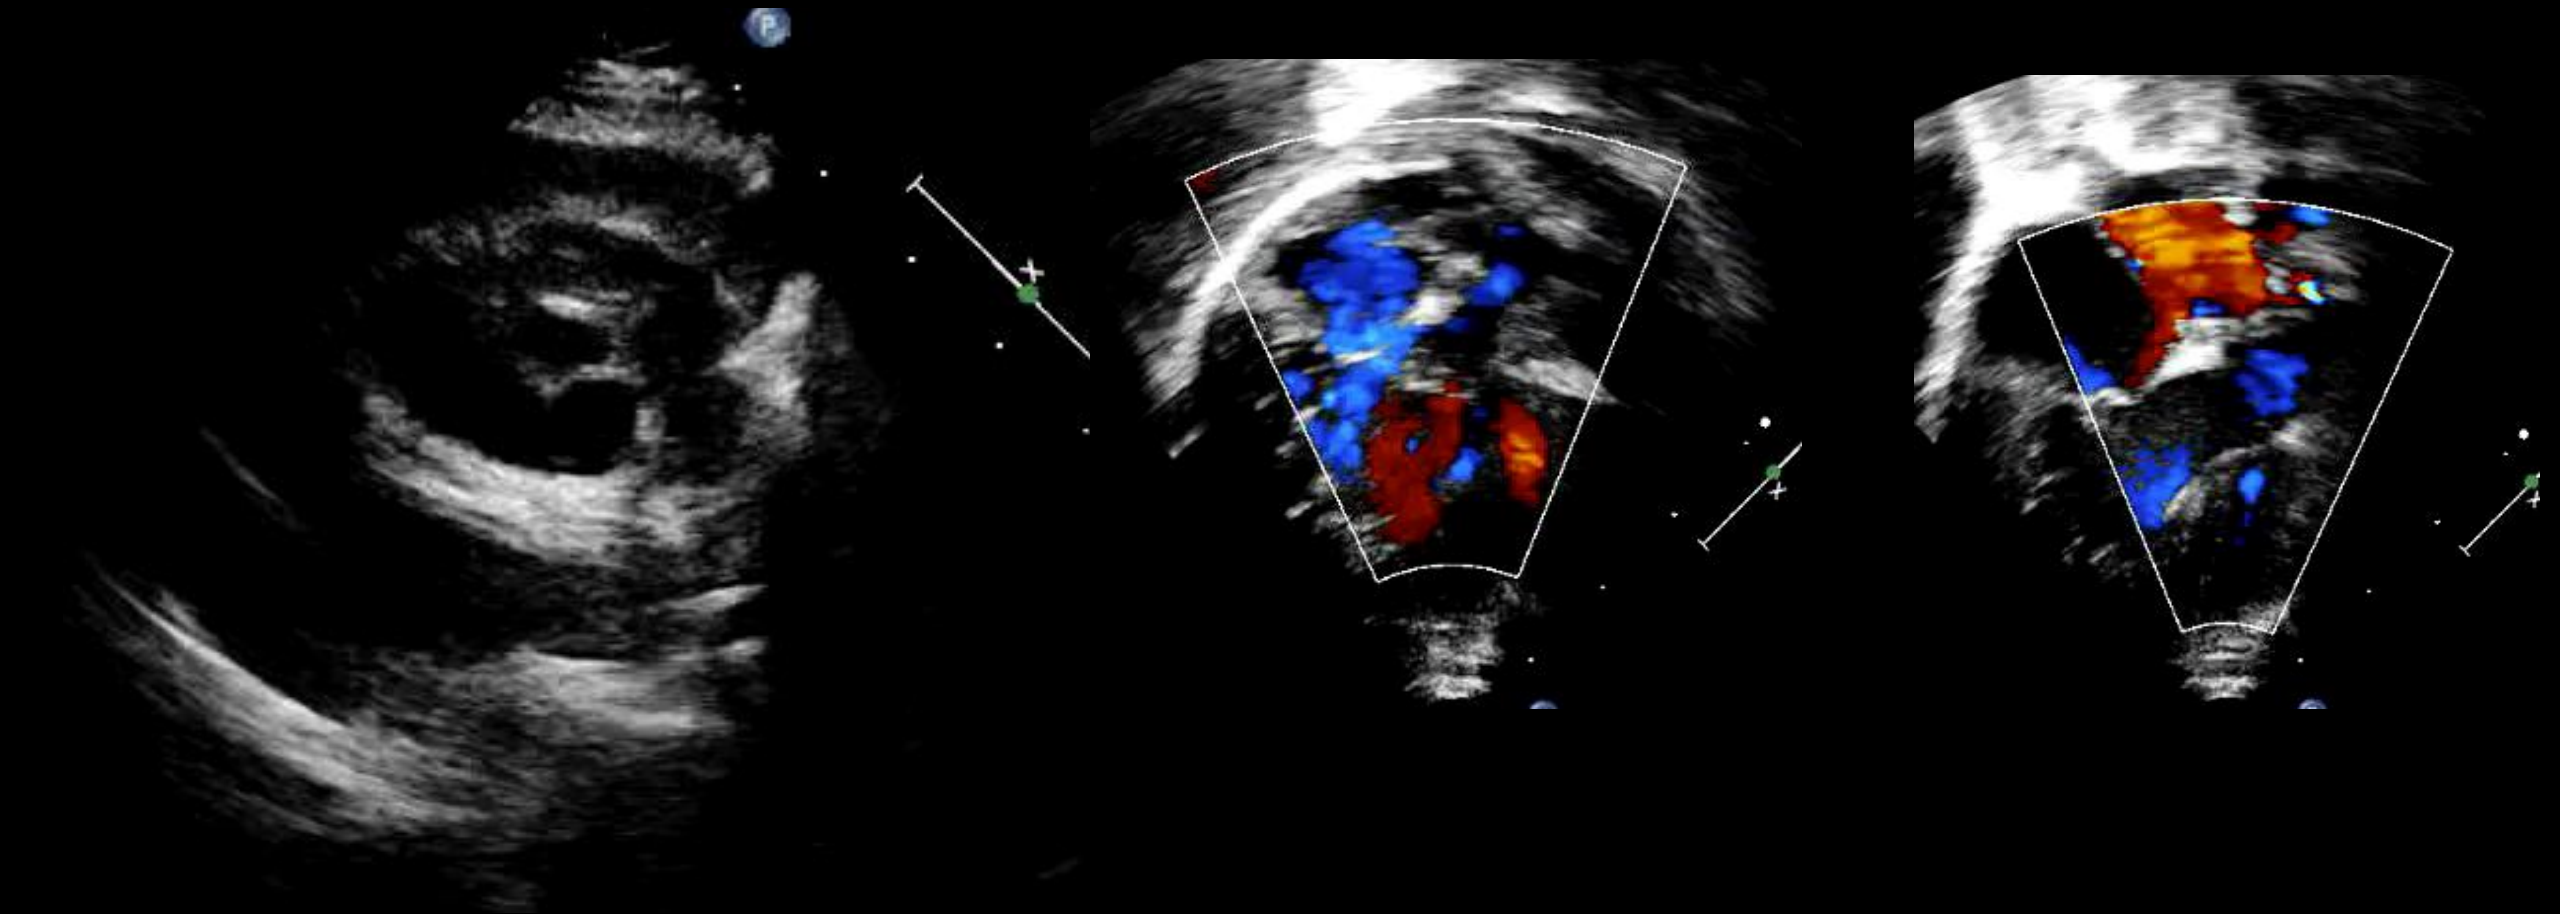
Vista Parasternal Longitudinal : Via de saída única aórtica do VD
